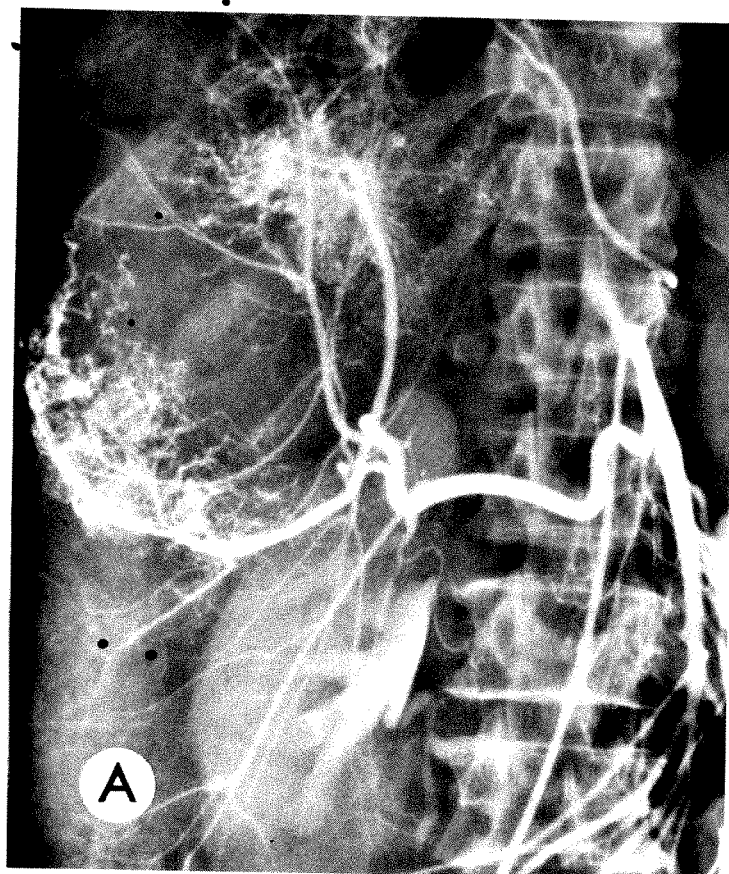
A, Angiogram showing vascular hepatoma in right lobe of liver. B, CT scan showing hepatoma as low density structure in posterior aspect of right lobe of liver.
